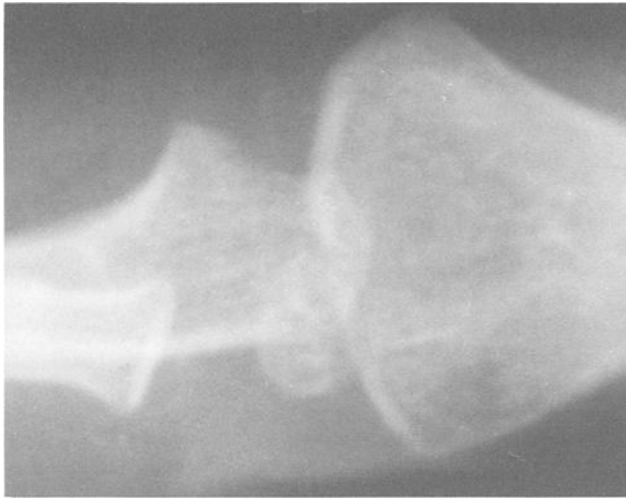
X-radiograph of the distal humerus and proximal radius and ulna.
